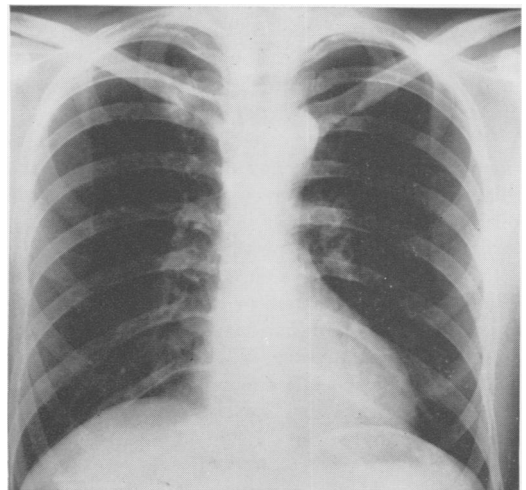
(c) Postoperative roentgenogram.
